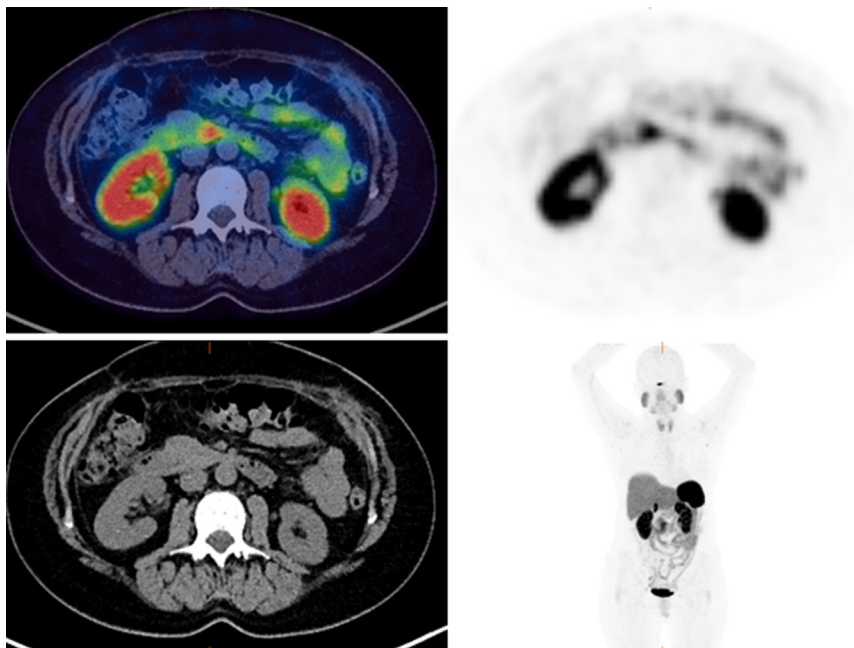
A 60-year-old patient who underwent a distal pancreatectomy in September 2013 for pancreatic NET. A subsequent CT demonstrated an area of arterial enhancement in segment 4A of the liver. ^{68}Ga -DOTATATE did not demonstrate any abnormal uptake in the liver. There is, however, intense uptake in the duodenum, which represents physiological uptake. Learning Point: Variable uptake can often be seen owing to variable excretion and receptor expression in normal cells. Any focal uptake however should be followed up.
